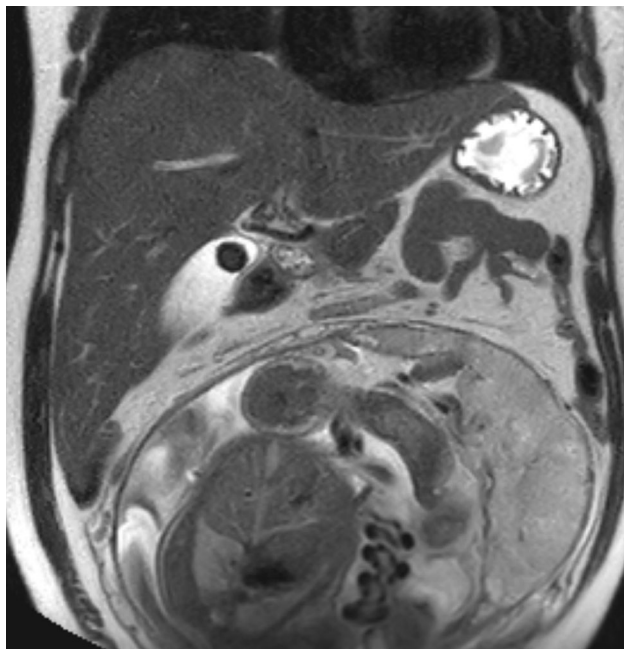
T2-weighted single-shot fast-spin echo coronal MR image of cholelithiasis without cholecystitis in a 41-year-old pregnant woman. There is a 2-cm calculus in the gallbladder
